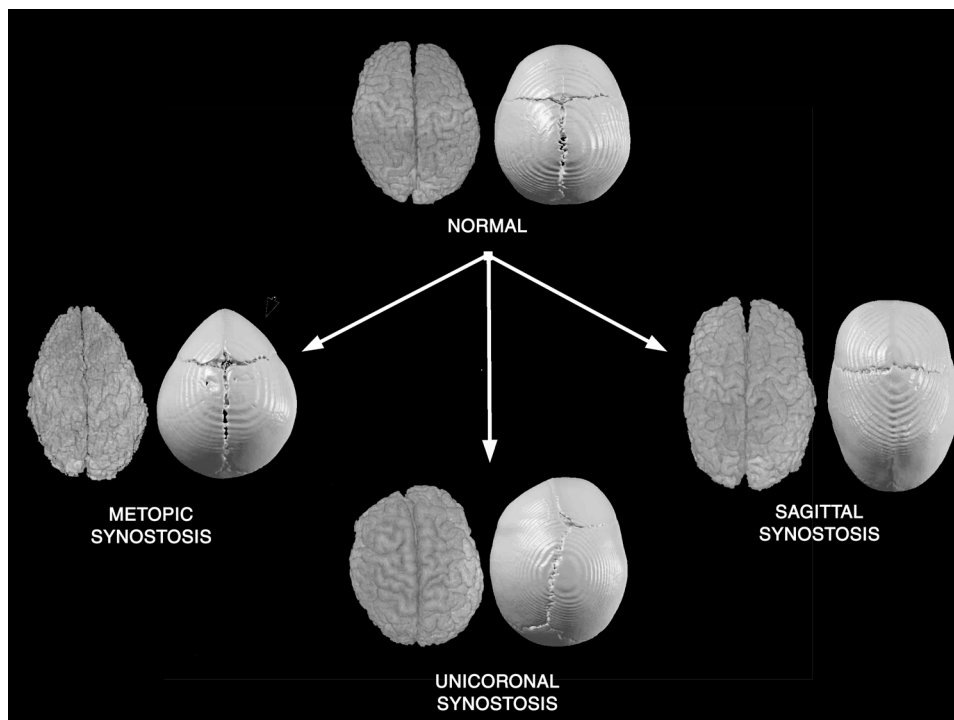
Three-dimensional reconstructions of computed tomography (CT) scans and magnetic resonance images (MRI) of children affected with three forms of isolated craniosynostosis – sagittal, metopic and uniconal, and one unaffected by craniosynostosis. These cases were chosen from our archive as examples of craniosynostosis phenotypes.
